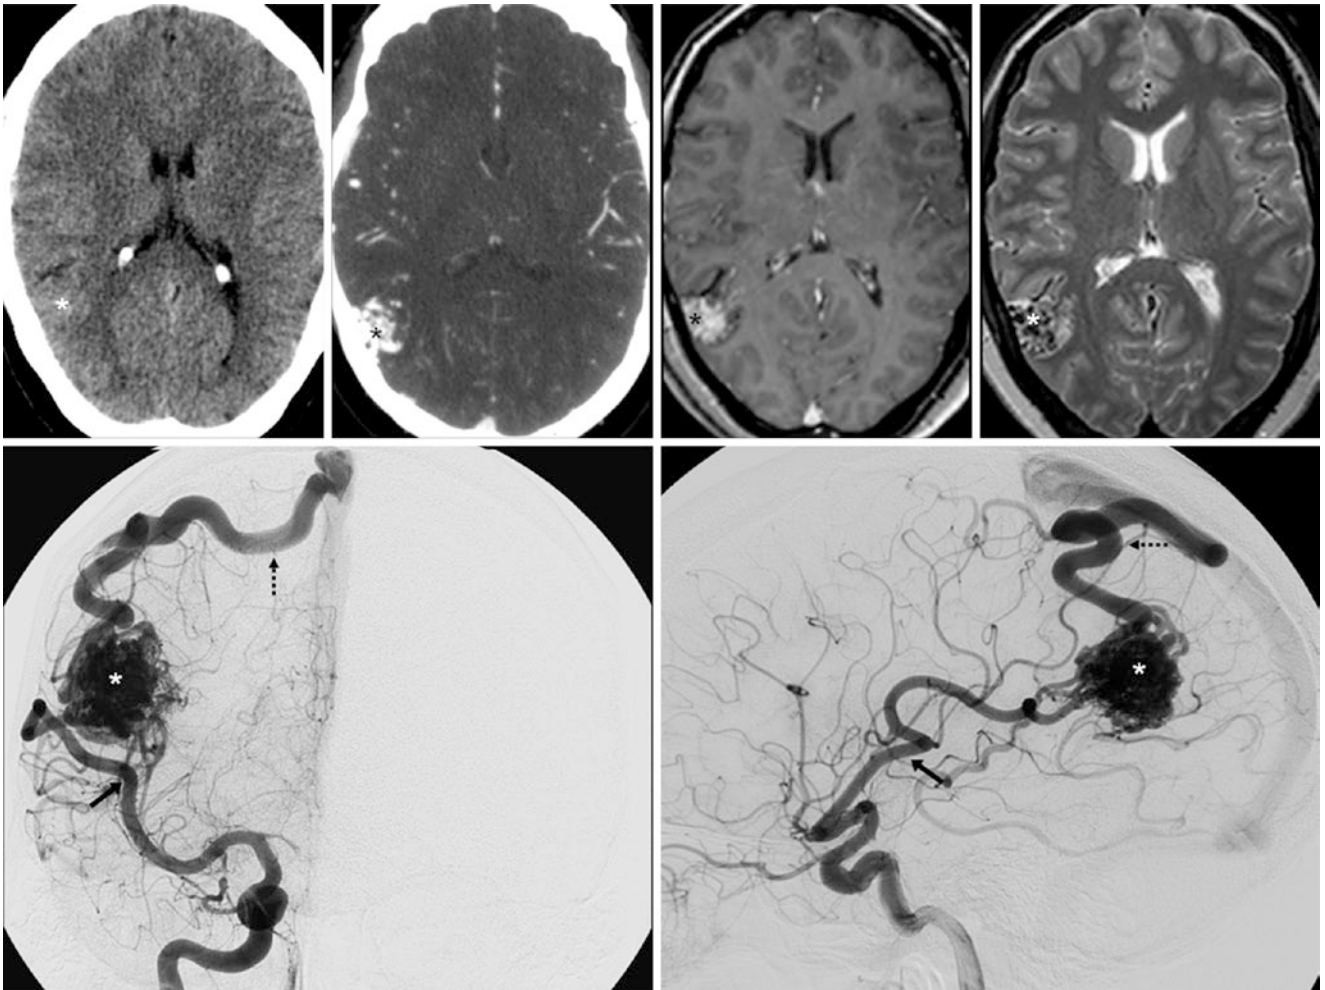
Comparison case of an AVM. A 28 year old had a dense parietal focus (*) on NECT (*top, left*), later confirmed to be an AVM nidus on CTA (*top, left middle*) and on a 1.5T MRI with postcontrast T1WI (*top, right middle*) and T2WI (*top, right*).
